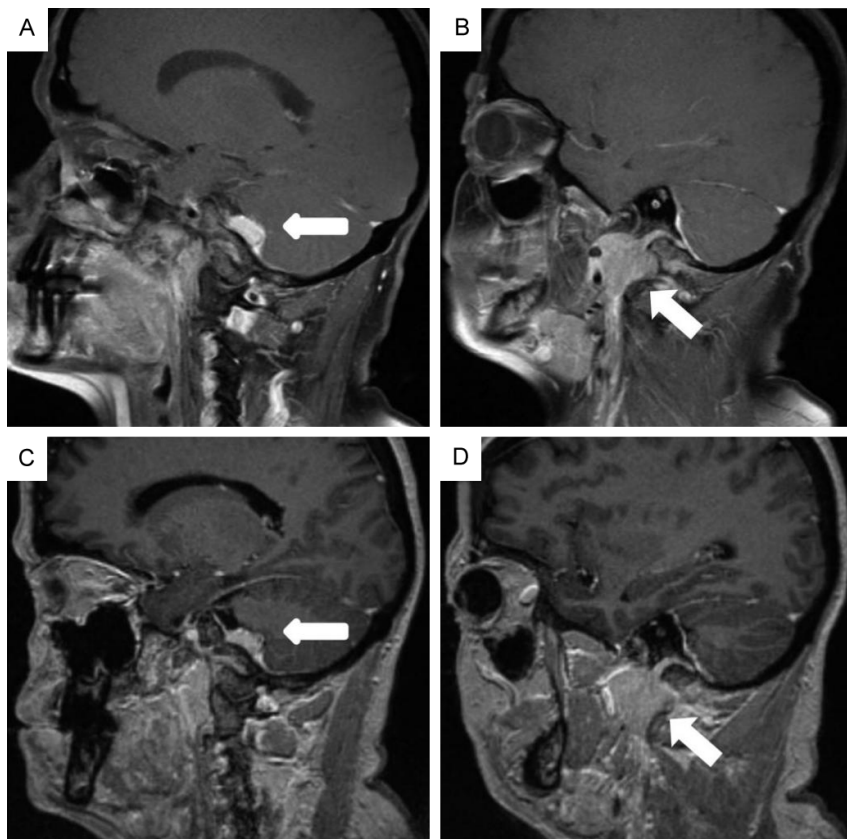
MRI demonstrating treatment response in a patient with WHO grade II meningioma after $[^{90}\text{Y}]$ Y-DOTATOC treatment. (A, B). Contrast-enhanced T1-weighted MR images at initiation $[^{90}\text{Y}]$ Y-DOTATOC therapy show enhancing tumor at the cerebellopontine angle extending into the upper cervical spine, with intracranial (A) and vertebral (B) involvement (arrows). (C, D) Follow-up MR imaging 72 months after $[^{90}\text{Y}]$ Y-DOTATOC therapy demonstrates sustained tumor control with stable appearance of the treated lesions (arrows). This research was originally published in JNM. Gerster-Gilliéron K et al. $[^{90}\text{Y}]$ Y-DOTATOC as a Therapeutic Option for Complex Recurrent or Progressive Meningiomas. J Nucl Med. November 2015, 56 (11) 1748-1751; © SNMMI [70].
